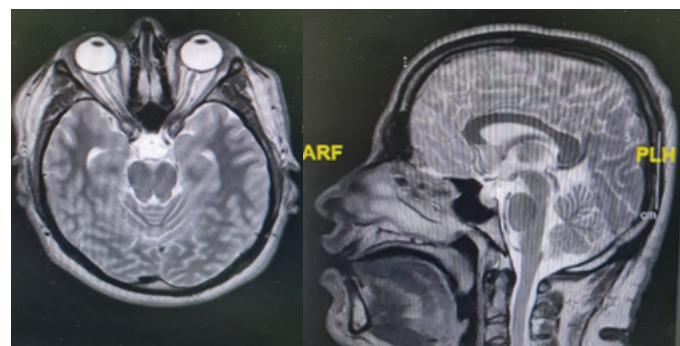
MRI brain of the third case suggestive of IIH
